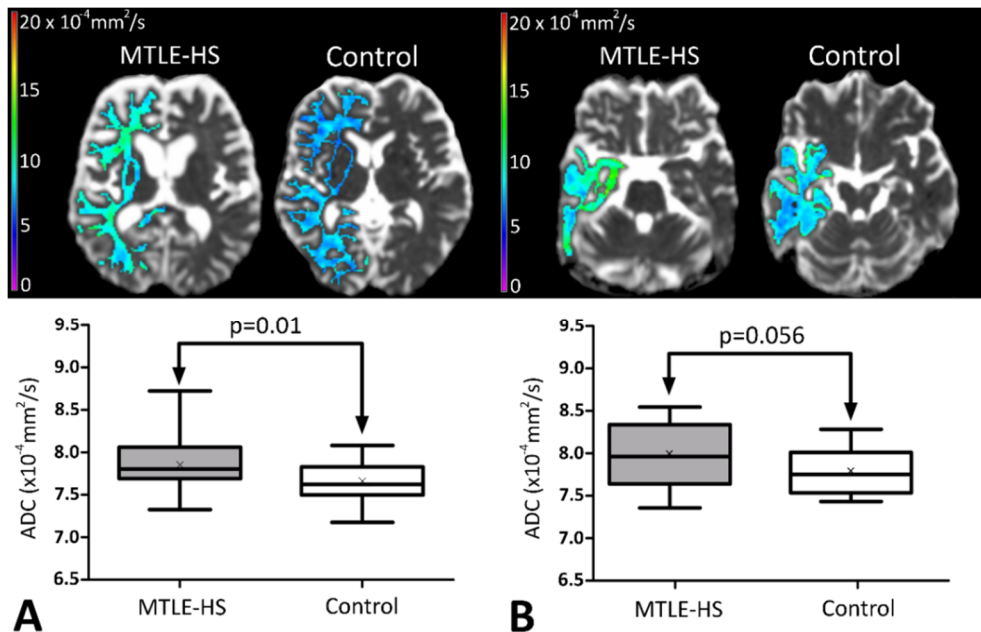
shows DWI images overlaid with color-coded ipsilateral hemispheric (upper left of A) and temporal lobe WM (upper right of B) ADC values in a representative MTLE-HS patient and a control subject. The box- and whiskers plots show the distribution of ADC values in the ipsilateral hemispheric (lower left of A) and temporal lobe WM (lower right of B) of MTLE-HS patients ( $N=22$ ) and control subjects ( $N=22$ ). The whiskers in the plot represent the minimum and the maximum ADC values, the cross depicts the mean while the band inside the box shows the median ADC.
